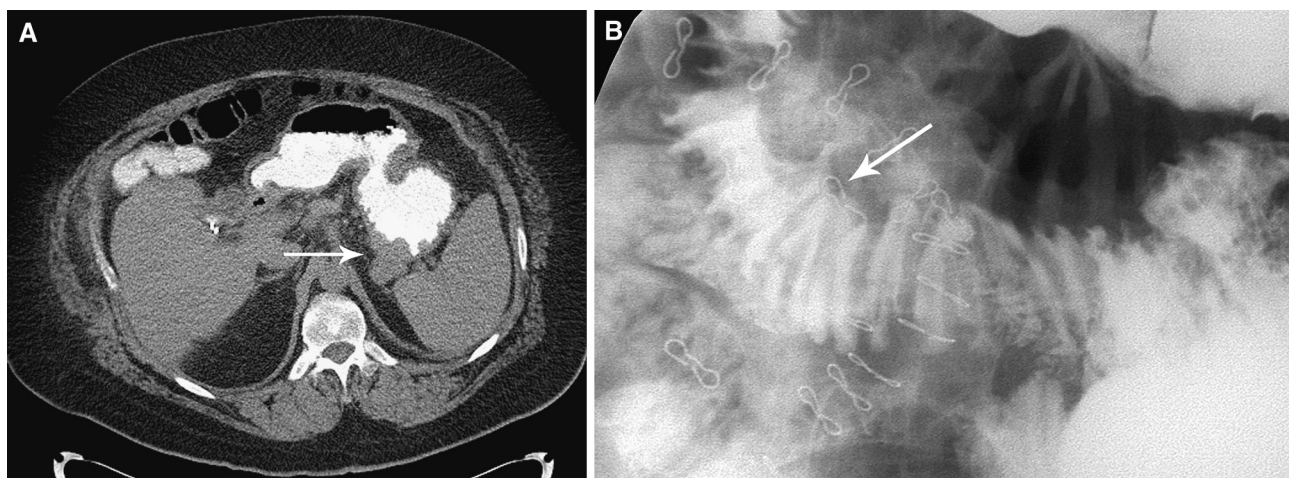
Gastrointestinal basidiobolomycosis in a 45-year-old man. A Computed tomography of the abdomen shows thickened gastric folds (arrow) in the fundus. B An upper gastrointestinal study shows thickened folds in the duodenum (arrow).
